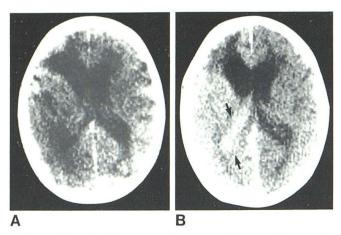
Case 19. Metastatic carcinoid tumors. Enhanced CT scans. A, Transverse-cut control scan. B, At about same level, after osmotic BBB modification. Enhancement of choroid plexus (*arrows*) indicates that barrier was opened in this structure, as well as in entire left cerebrum.
